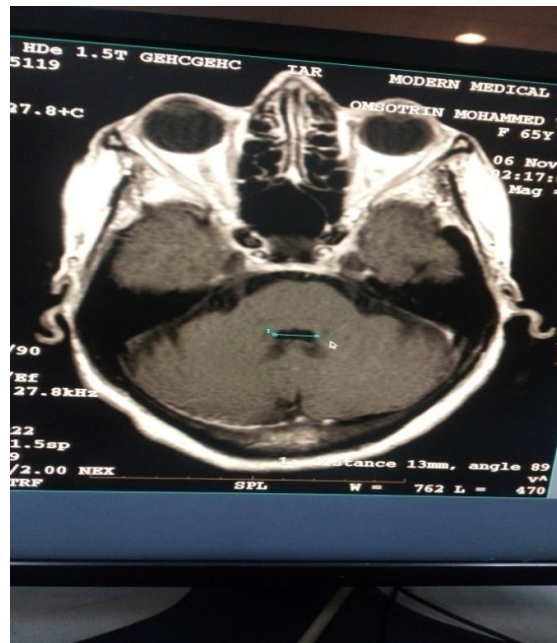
axial magnetic resonance image at level of fourth ventricle, showing how the measurement of the width was taken.
